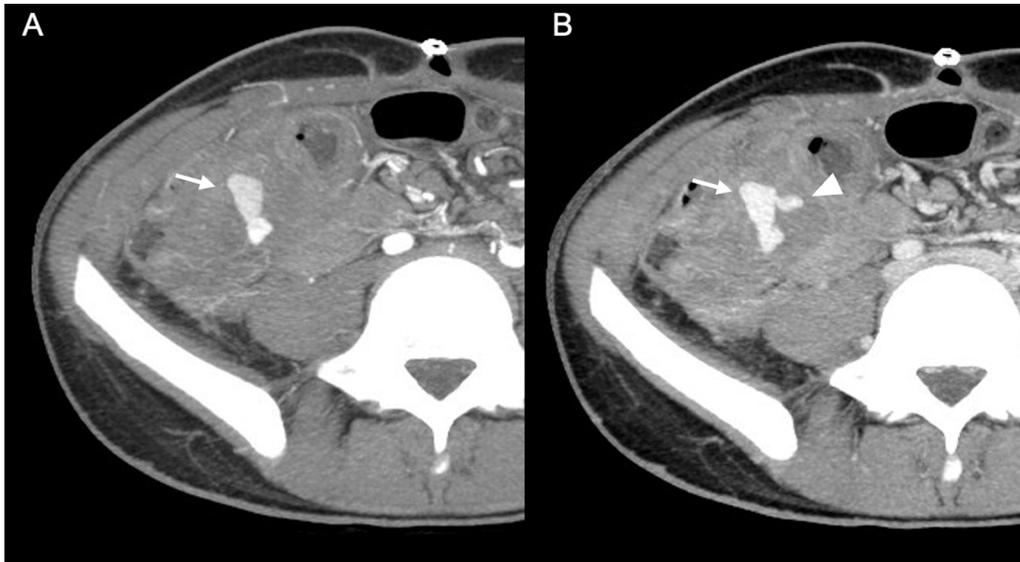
14-year-old male with abdominal pain, hypotension and rectorrhagia after recent surgery for acute appendicitis with peritonitis. Axial maximum intensity projection reconstructions of CT angiography of the abdomen and pelvis in arterial (A) and venous (B) phases showing a bilobed pseudoaneurysm (arrow) of the ileocolic artery in the surgical bed. It is accompanied by a focal area of active contrast extravasation (arrowhead) that is evident in the venous phase (B), related to bleeding due to rupture of the pseudoaneurysm.
